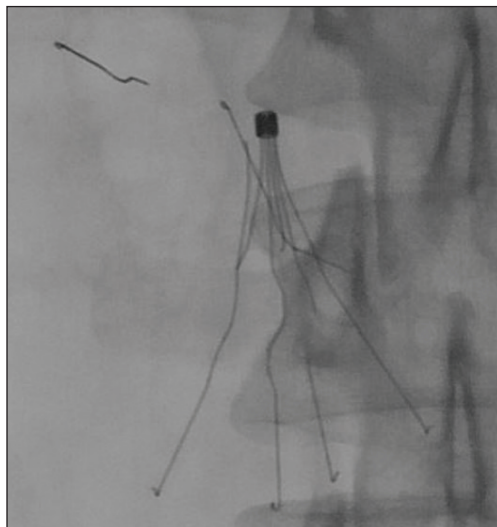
Spot radiograph of the abdomen demonstrates an IVC filter with multifocal fractures. One fractured leg can be seen in the extra-vascular space within the retroperitoneum.
